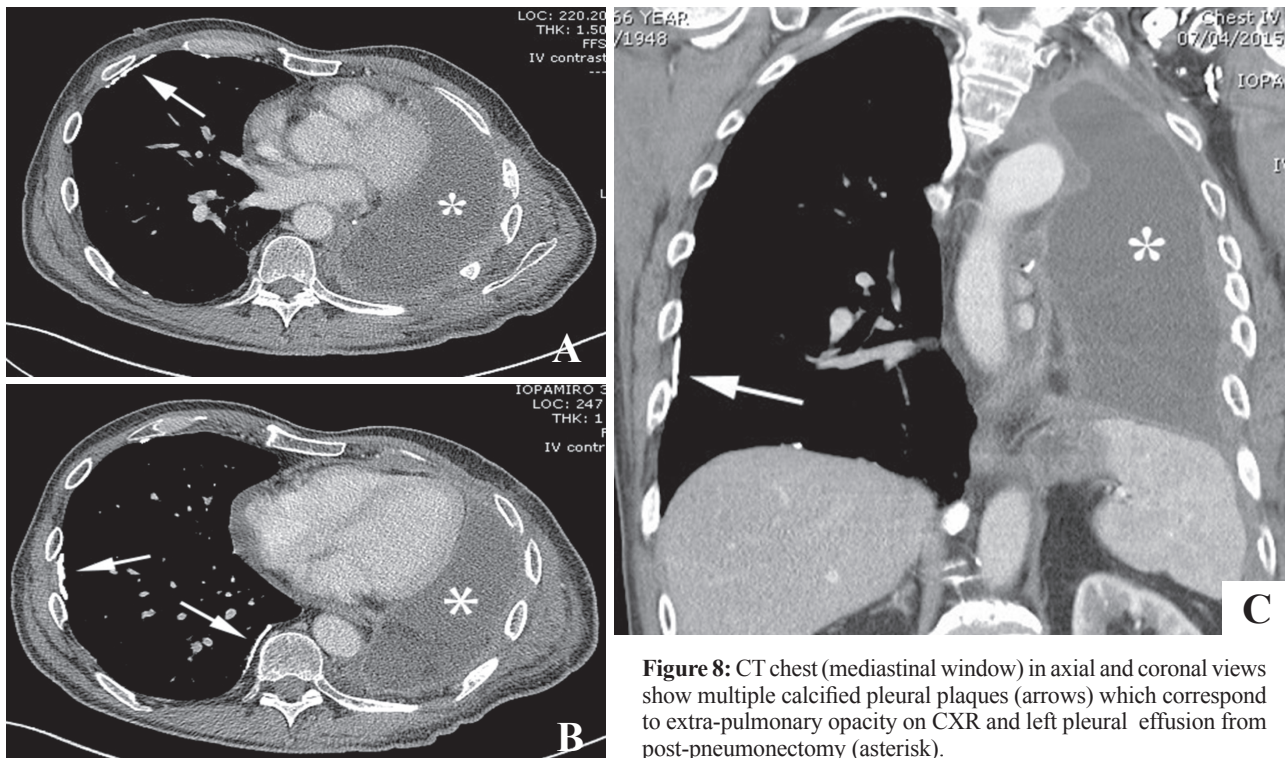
CT chest (mediastinal window) in axial and coronal views show multiple calcified pleural plaques (arrows) which correspond to extra-pulmonary opacity on CXR and left pleural effusion from post-pneumonectomy (asterisk).
